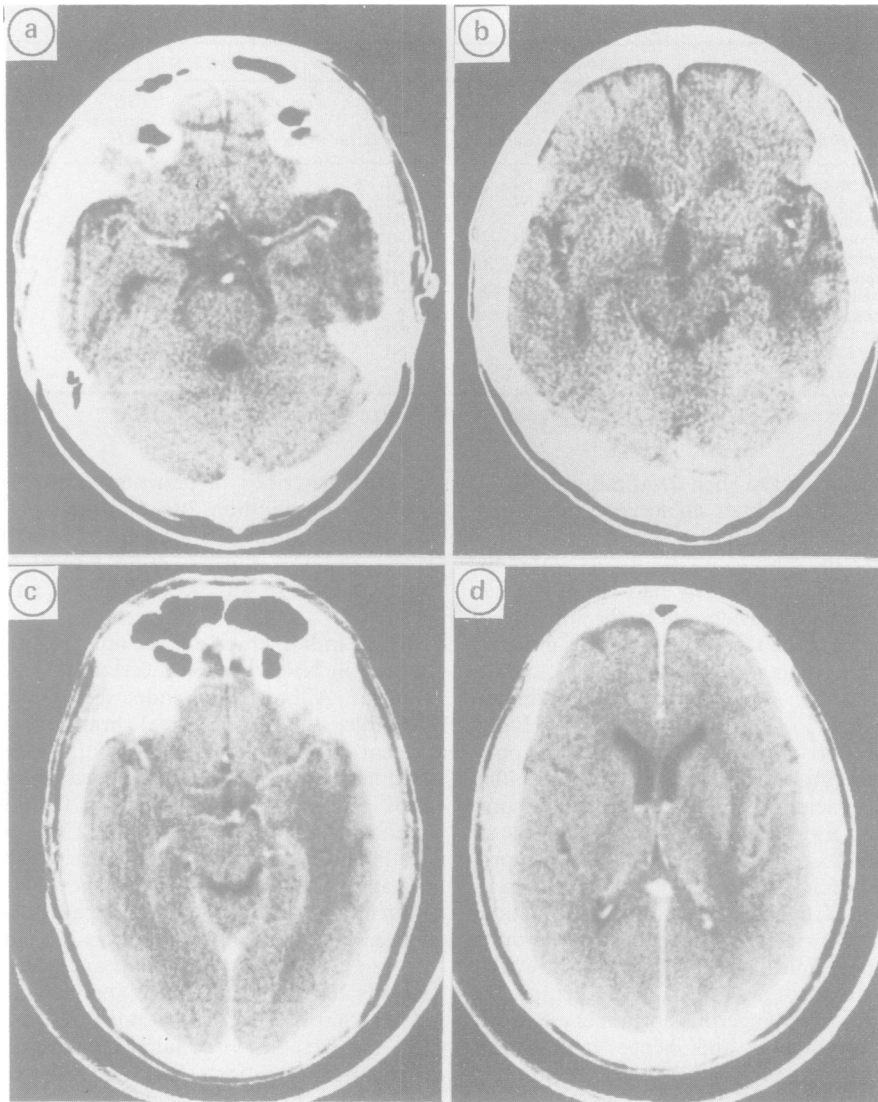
Fig (a, b) Patient 2. Contiguous 10 mm CT slices with intravenous contrast showing an area of decreased attenuation in the left temporal lobe. No mass effect with minimal contrast enhancement. (c, d) Patient 6. Enhanced CT scan showing bitemporal hypodense areas worse on the left, with mild mass effect. Note the extension into the adjacent frontal and parietal lobes.
